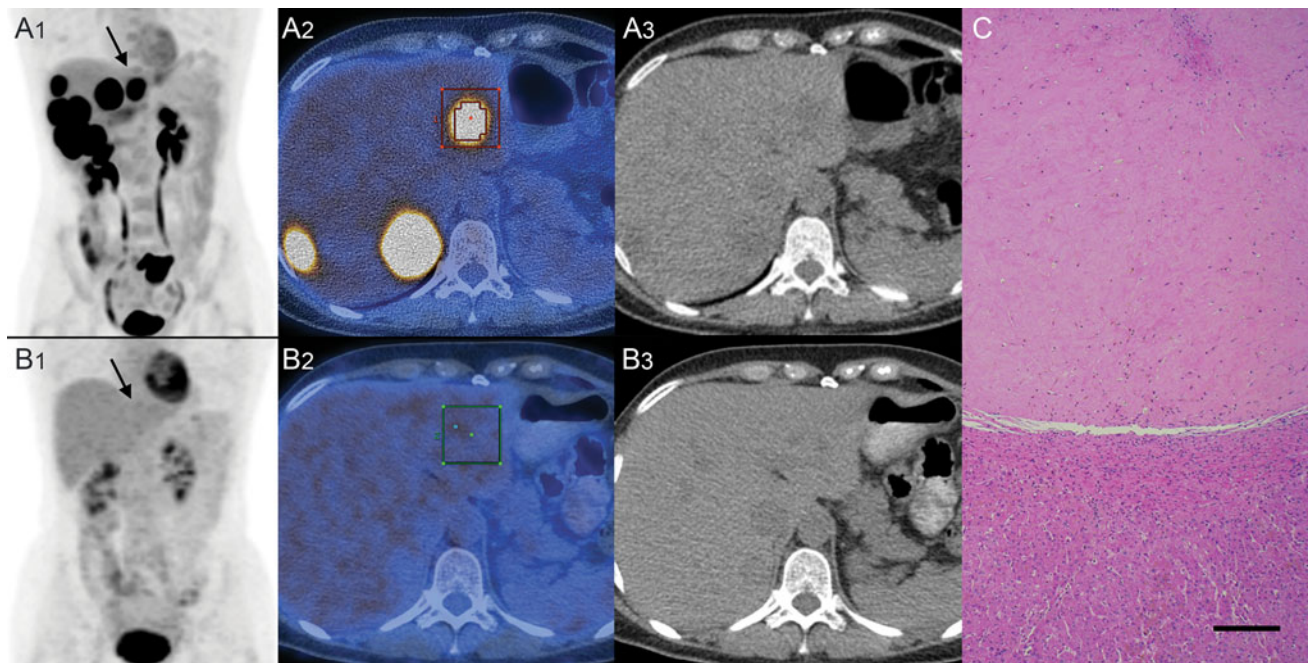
51-year-old woman with hepatic metastases of a sigma carcinoma pT4 N1 M1. a_{1–3} Extensive FDG active liver metastases in both lobes in the initial PET/CT (18 June 2009) the lesion in liver segment II was selected (arrow). (a₁) The lesion was well delineated on axial PET/CT images (a₂), but not well demarcated on axial unenhanced
